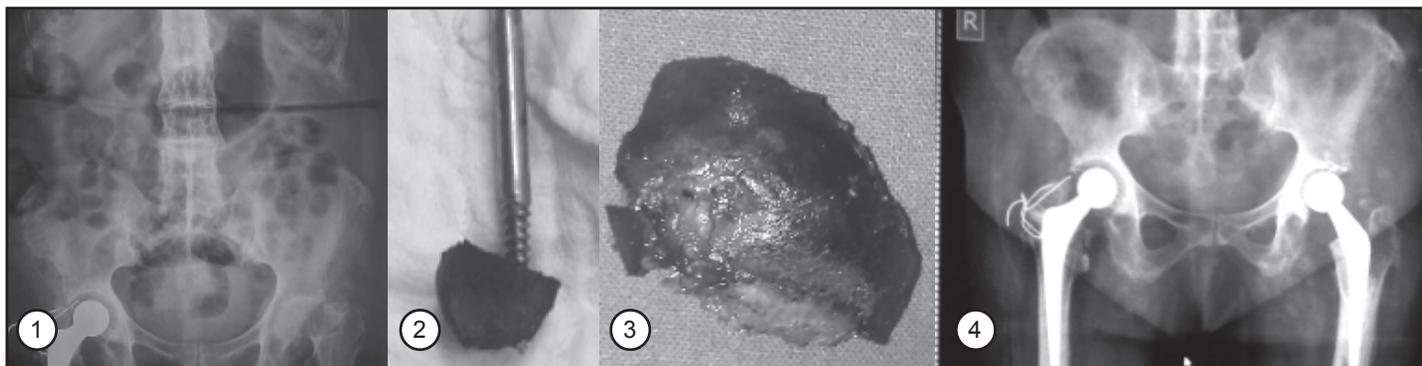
Pre-operative X-ray showing pathological fracture in the neck of femur with arthritic changes left hip, THR on the right side with spondylotic changes in the lumbar spine. Figure 2 & 3: Black discolouration of the head of the femur removed during surgery Figure 4: Post-operative X-ray, THR on left side also.
